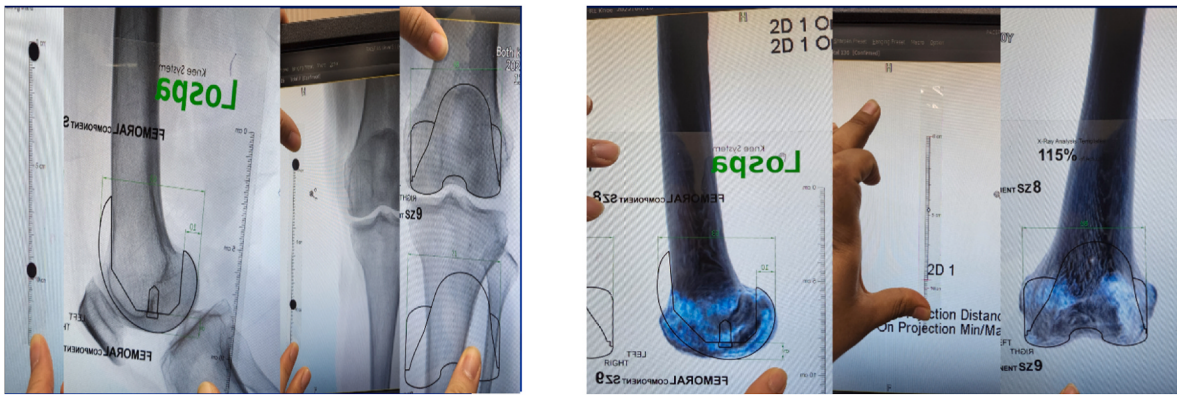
Pre-operative templating of the knees using computed tomography (CT) scan and X-rays.
